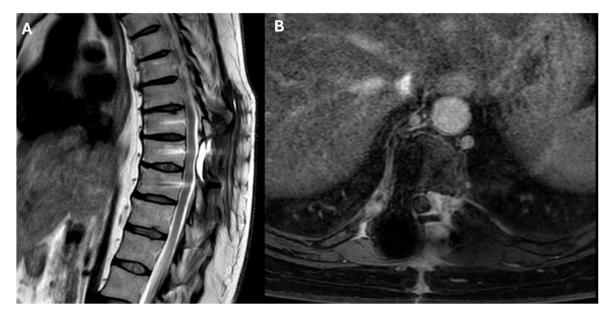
Postoperative thoracic spine MRI. Sagittal T2-weighted image (A) and axial T1-weighted image (B) with Gadolinium contrast from the one-month follow-up thoracic spinal MRI confirm the recent surgical resection of the Th9–Th10 dumbbell meningioma. This picture is from S. Elia Hospital, Caltanissetta, Italy, and informed consent was obtained from the patient for this study.
